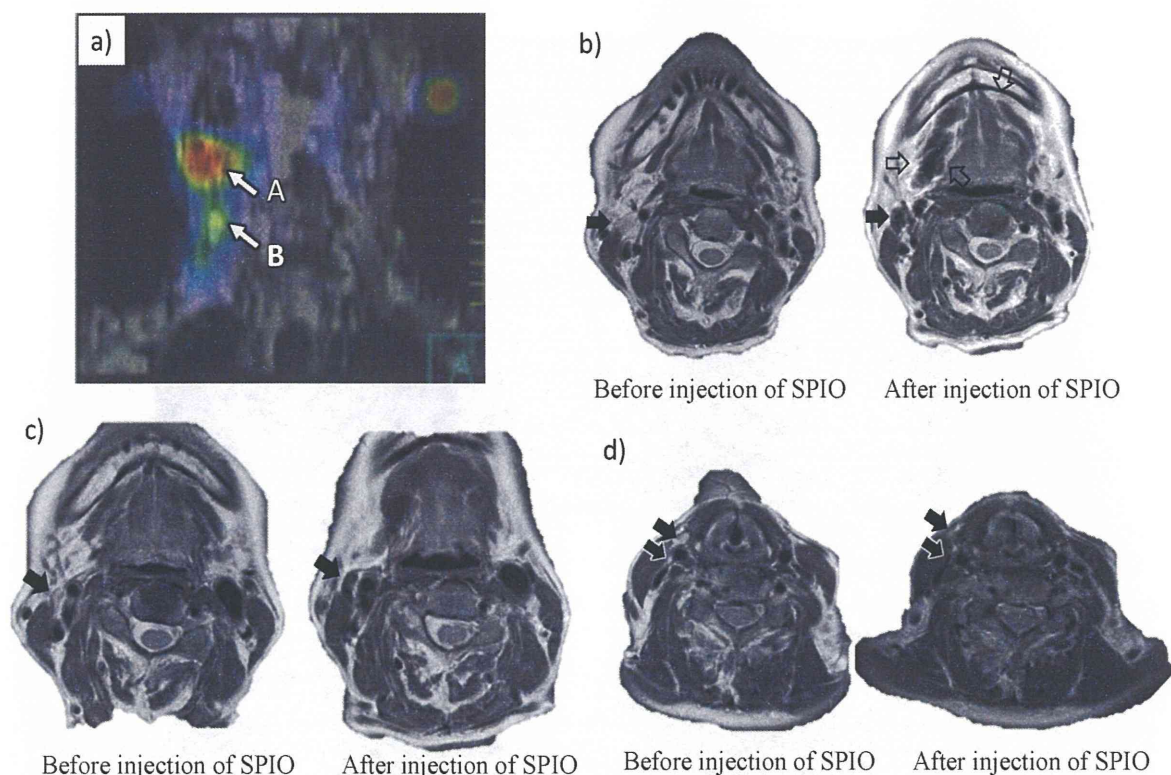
Case1; a) The locations of SLNs were identified by SPECT. b and c) The signal attenuation was shown by MRI (T2W, closed arrows). SPIO around the primary lesion was surrounded by open arrows. Those lymph nodes anatomically coincided with the hot spot A in photo a. d) Other lymph nodes with signal attenuation were detected by MRI (T2W, closed arrows). They were anatomically coincided with the lower part of hot spot B in photo a.
